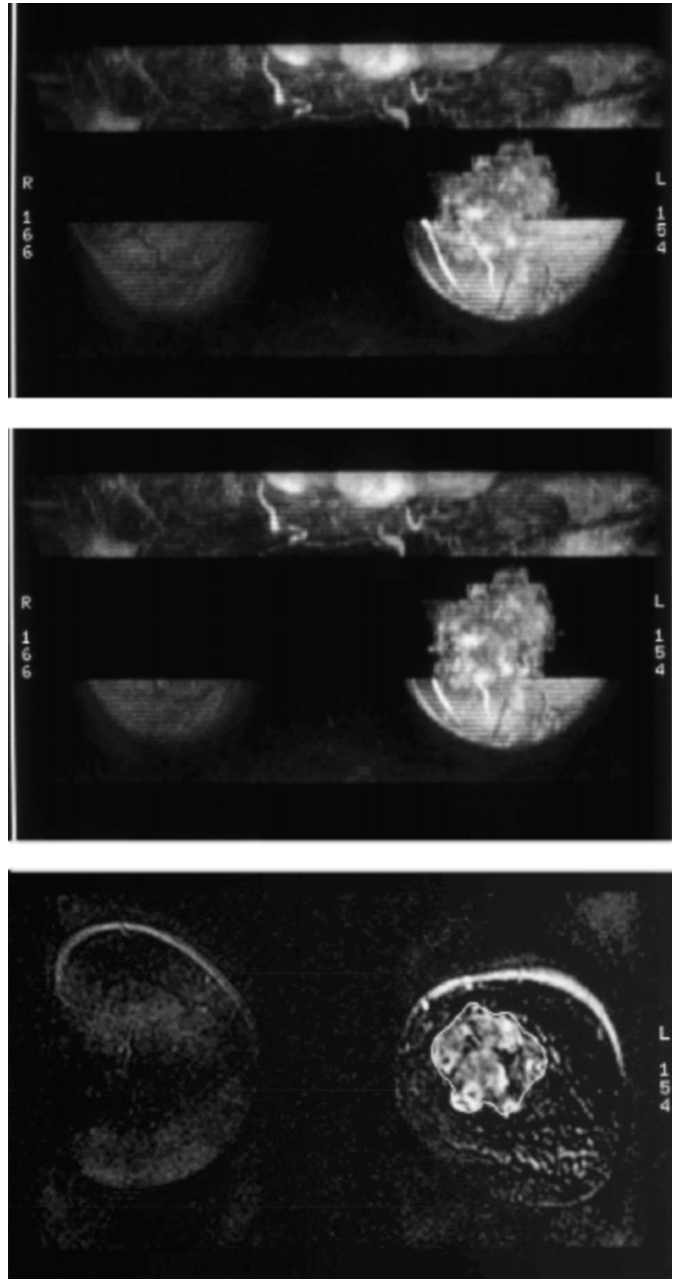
MRI (axial and coronal MIP reconstruction): by cutting the enhancement area slice by slice on the coronal plane (f) the shape of the lesion is traced on the axial plane (g, h).
